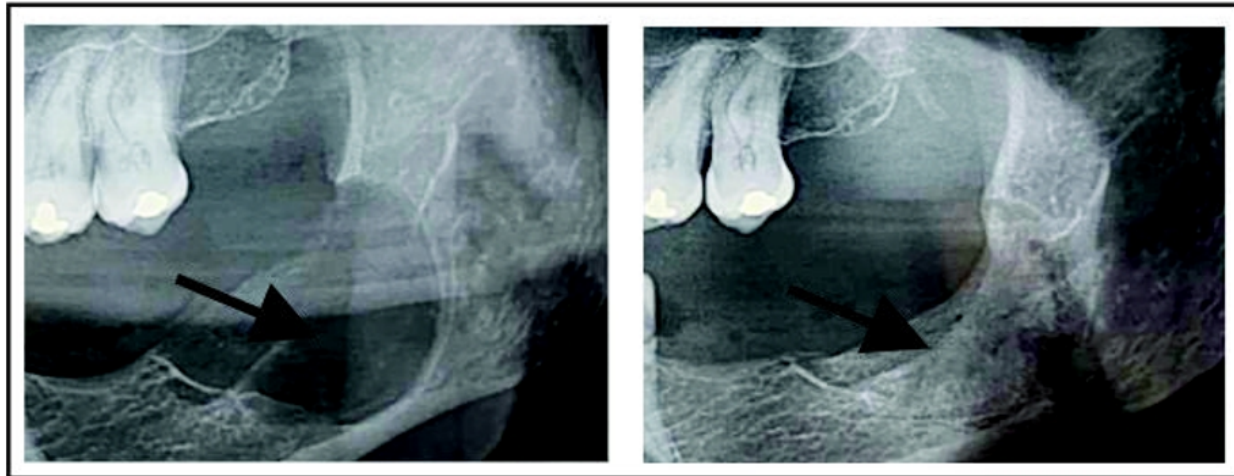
X-ray images of patient with mandibular cyst (arrow) before (left) and after 90 days with cHA graft (right). Images from a case at the clinic of one of the authors (PJV), used with informed consent.
